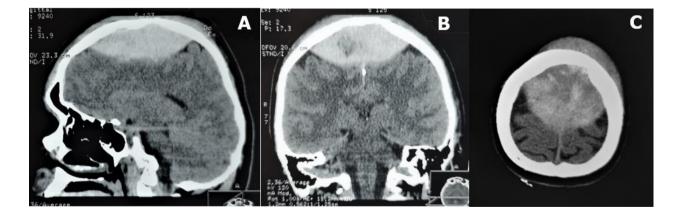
The sagittal (A), coronal (B) and axial (C) CT tomograms show a hyperdense convex collection corresponding to acute bifrontoparietal EDH. The cerebral parenchyma and upper sagittal sinus are displaced caudally.
